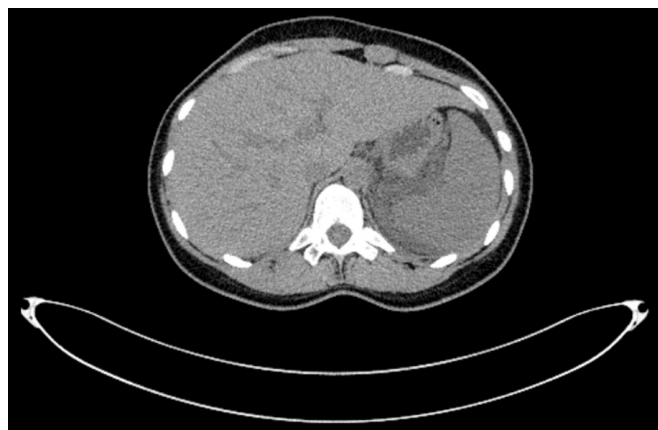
CT scan with the liver and the spleen; both appear enlarged and the medial part of the spleen is in contact with pancreatic inflammatory tissue.
